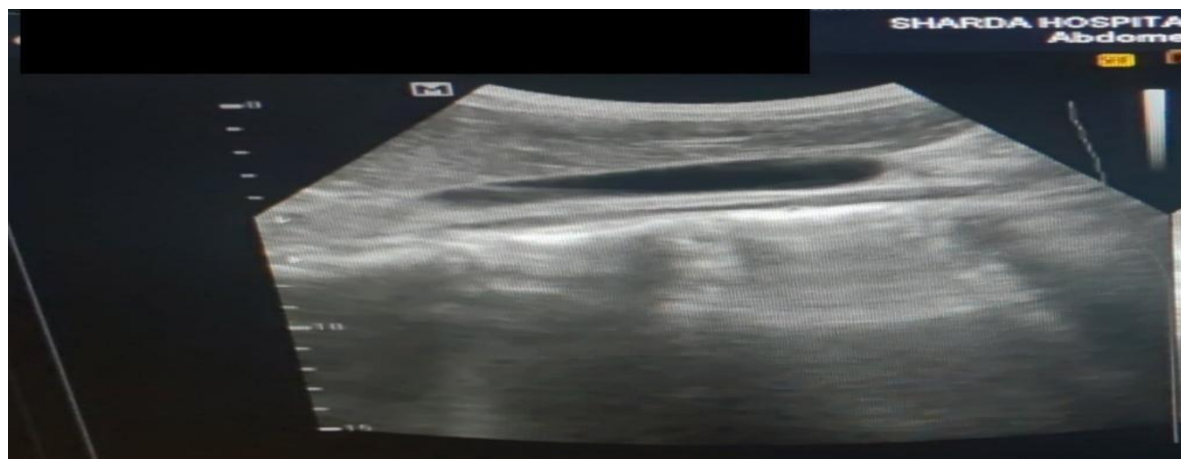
Ultrasound image of gall bladder showing no sludge on initiation of ceftriaxone therapy .
